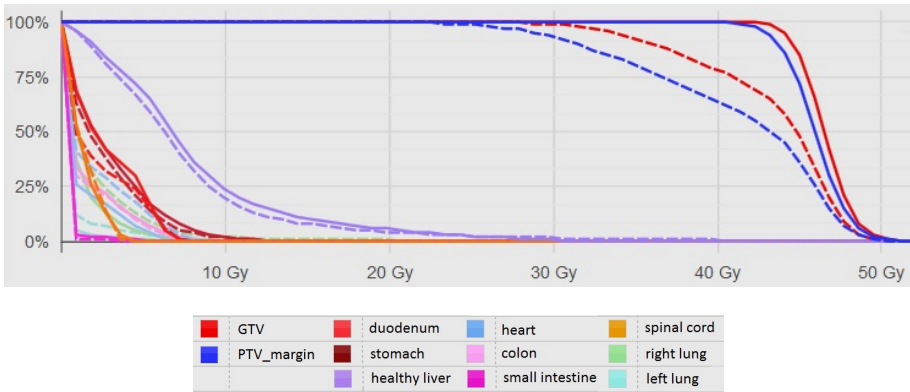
DVHs for 3D dose distribution calculated by MCS on the 4D_Ph1 CT images and 3D dose distribution calculated by MCS on the 4D_Ph4 CT images (dashed line), for patient 3 without CTV margin
